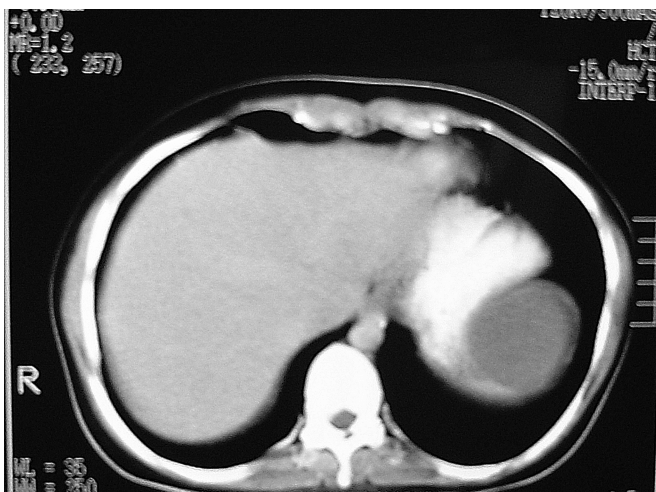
Computed tomographic scan of abdomen demonstrating splenic cyst.
